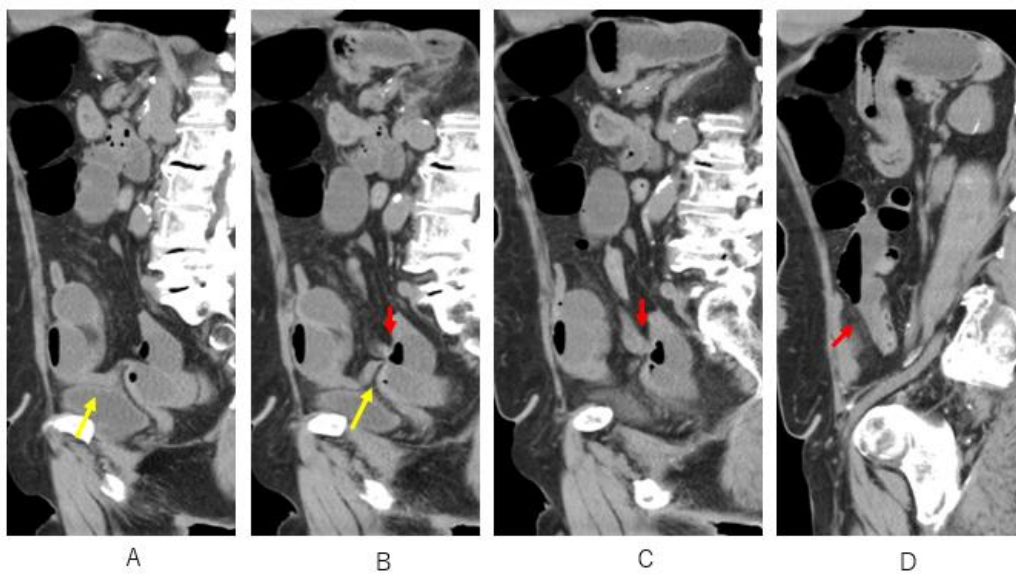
There is a double beak sign on sagittal CT; one is a red arrow that indicates one beak between oral-sided dilated small bowel (B, C, D) and closed dilated bowel (B, C): another is a yellow arrow between anal-sided constrictive (A, B) bowel and closed dilated bowel (A, B).
